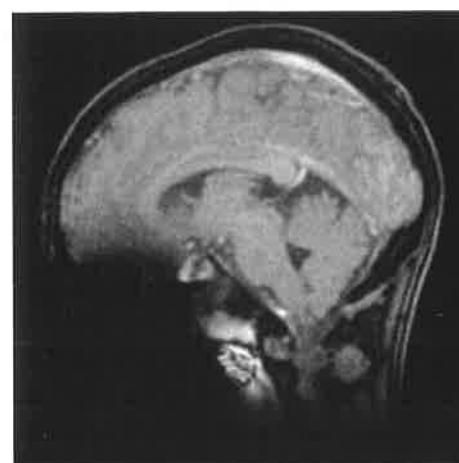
MRI scan of patient with metal orthodontic brackets in place
